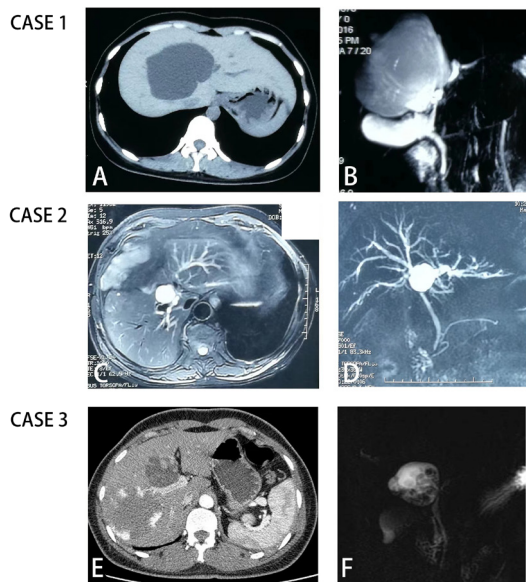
Imaging findings of the 3 cases of solitary intrahepatic biliary cyst. Case 1, abdominal CT (A) showed after biliary cyst surgery+subtotal gastrectomy, cyst lesion recurrent in the right liver lobe; MRCP (B) revealed single cystic lesion in the hilum, involving the left medial lobe and right anterior lobe. Case 2, MRCP (C, D) revealed after resection of biliary cyst+cholecystectomy+choledochojunctionostomy, intrahepatic biliary dilatation recurrent. Case 3, abdominal CT (E) showed cavernous hemangioma in the right liver lobe and biliary cyst in the left liver lobe. MRCP (F) showed biliary cyst in the left liver lobe, and large possibility of cavernous hemangioma in the right liver lobe.
